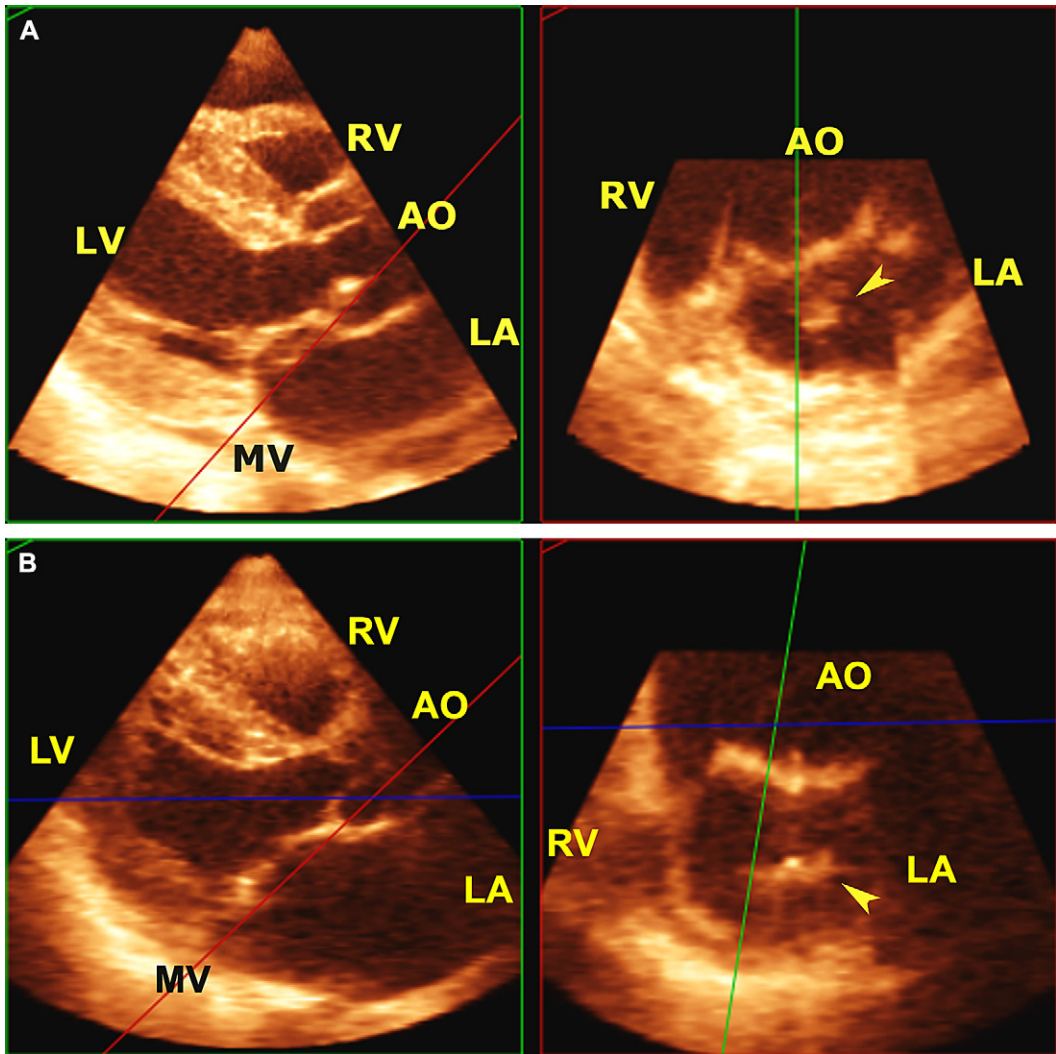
Live/real-time 3D transthoracic echocardiography in the assessment of mitral valve prolapse using parasternally acquired data sets and offline Q laboratory 4.1 software. (A, B) The cropping plane (red) was placed at the level of mitral valve annulus in parasternal long axis view (left panels) and the prolapsing segment identified in the corresponding short axis view (right panels). The position of aorta (AO) and the right ventricle (RV) was used for anatomical orientation. Anterior mitral valve (MV) leaflet prolapse will appear in the left atrium anteriorly (adjacent to aorta), while posterior leaflet prolapse will be located more posteriorly. Depending on whether prolapsing MV leaflet tissue is located medially toward the ventricular septum, in the middle, or laterally, posteromedial (A3/P3), middle (A2/P2), and anterolateral (A1/P1) segment/scallop prolapse can be identified. Arrowheads show A2 prolapse in A and P2 prolapse in B. Abbreviation: LA, left atrium. (Reproduced from Patel V, Hsiung MC, Nanda NC, et al. Usefulness of live/real-time 3D transthoracic echocardiography in the identification of individual segment/scallop prolapse of the mitral valve. *Echocardiography* 2006;23:513–8; with permission.)
